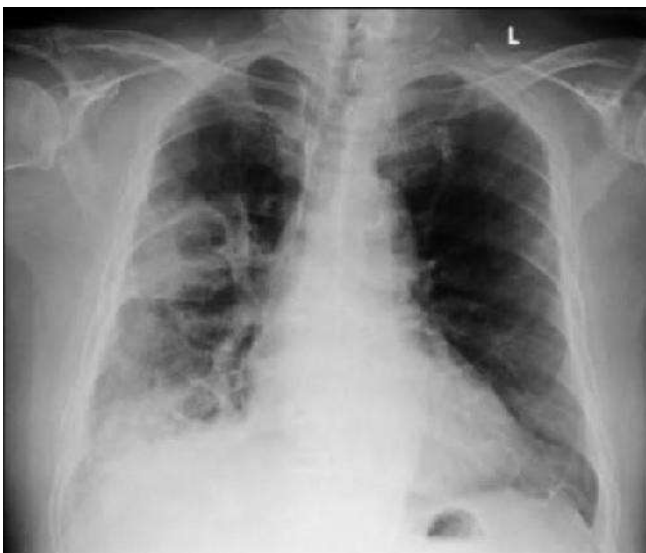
Chest X-Ray on current state, showed areas of consolidation with cavitation in right mid and lower lobes
